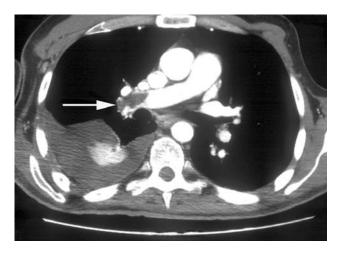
Computed tomography scan of the chest showing a near-occlusive thrombus in the right main pulmonary artery (arrow)
